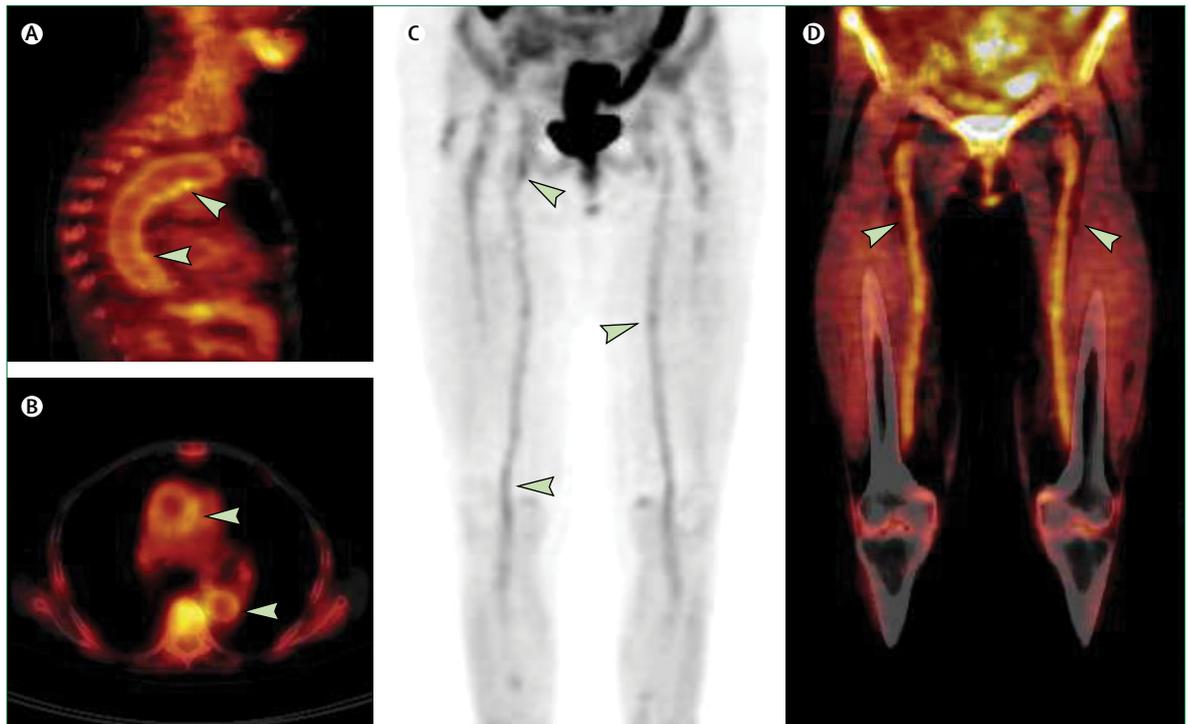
^{18}F -fluorodeoxyglucose integrated with PET and CT images
